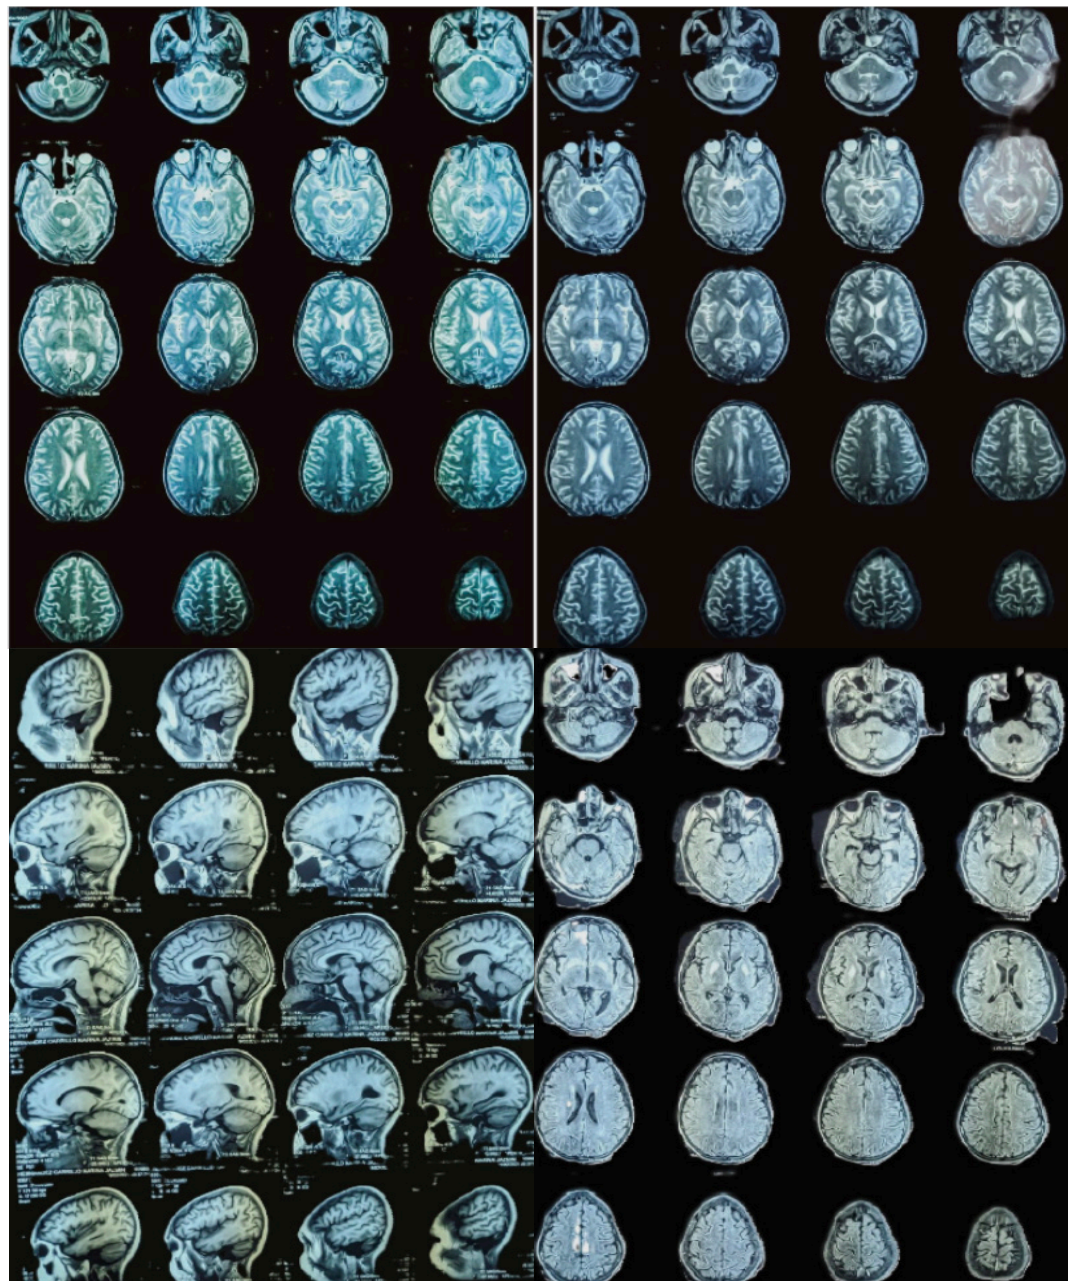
Brain MRI. Foci of hyperintense signal at basal ganglia level T2 and FLAIR sequences with mild atrophic changes, ventricular system permeable and without abnormalities. Inflammatory signs in ethmoidal, sphenoidal, and left frontal sinuses and inflammatory signs at the left mastoid level in addition to a symmetrical hyperintense signal of basal ganglia.
